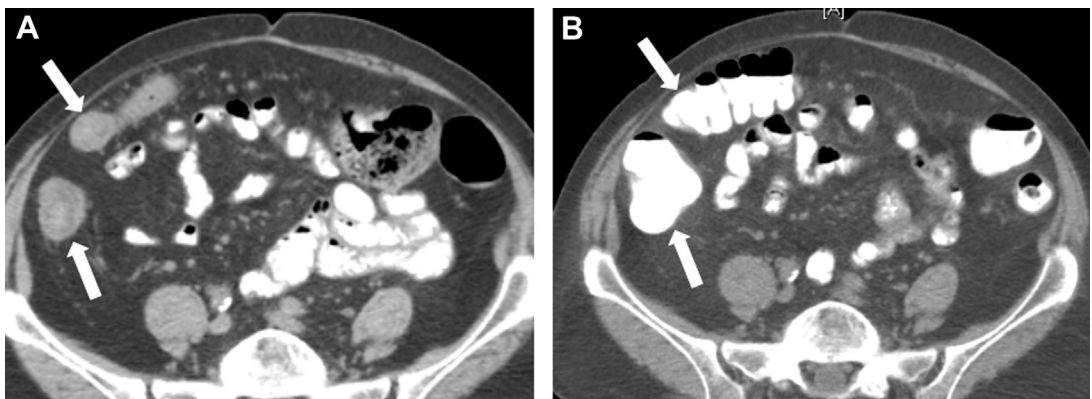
Under-distended colon mimicking colitis. A 72-year-old woman with generalized abdominal pain. Axial CT image (A) shows apparent wall thickening of the under-distended right colon (arrows), which could erroneously raise concern for colitis. Image from repeat CT performed 1 hour later (B), however, demonstrates oral contrast progression into the right colon, which now is well opacified and with normal wall thickness (arrows).
